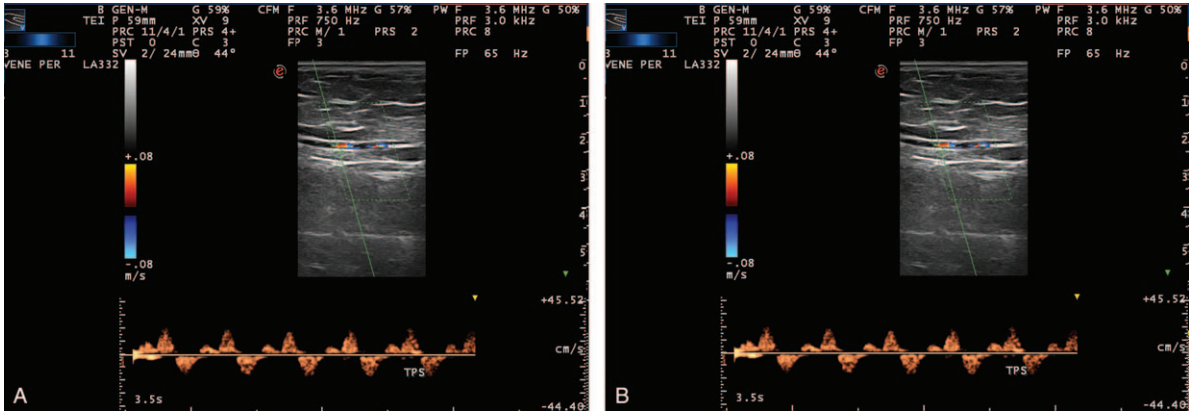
Patient 4 at age 15 years: color Doppler ultrasound examination of the right lower leg showing (A) normal laminar flow; and (B) larger diameter of the right limb vessels.
